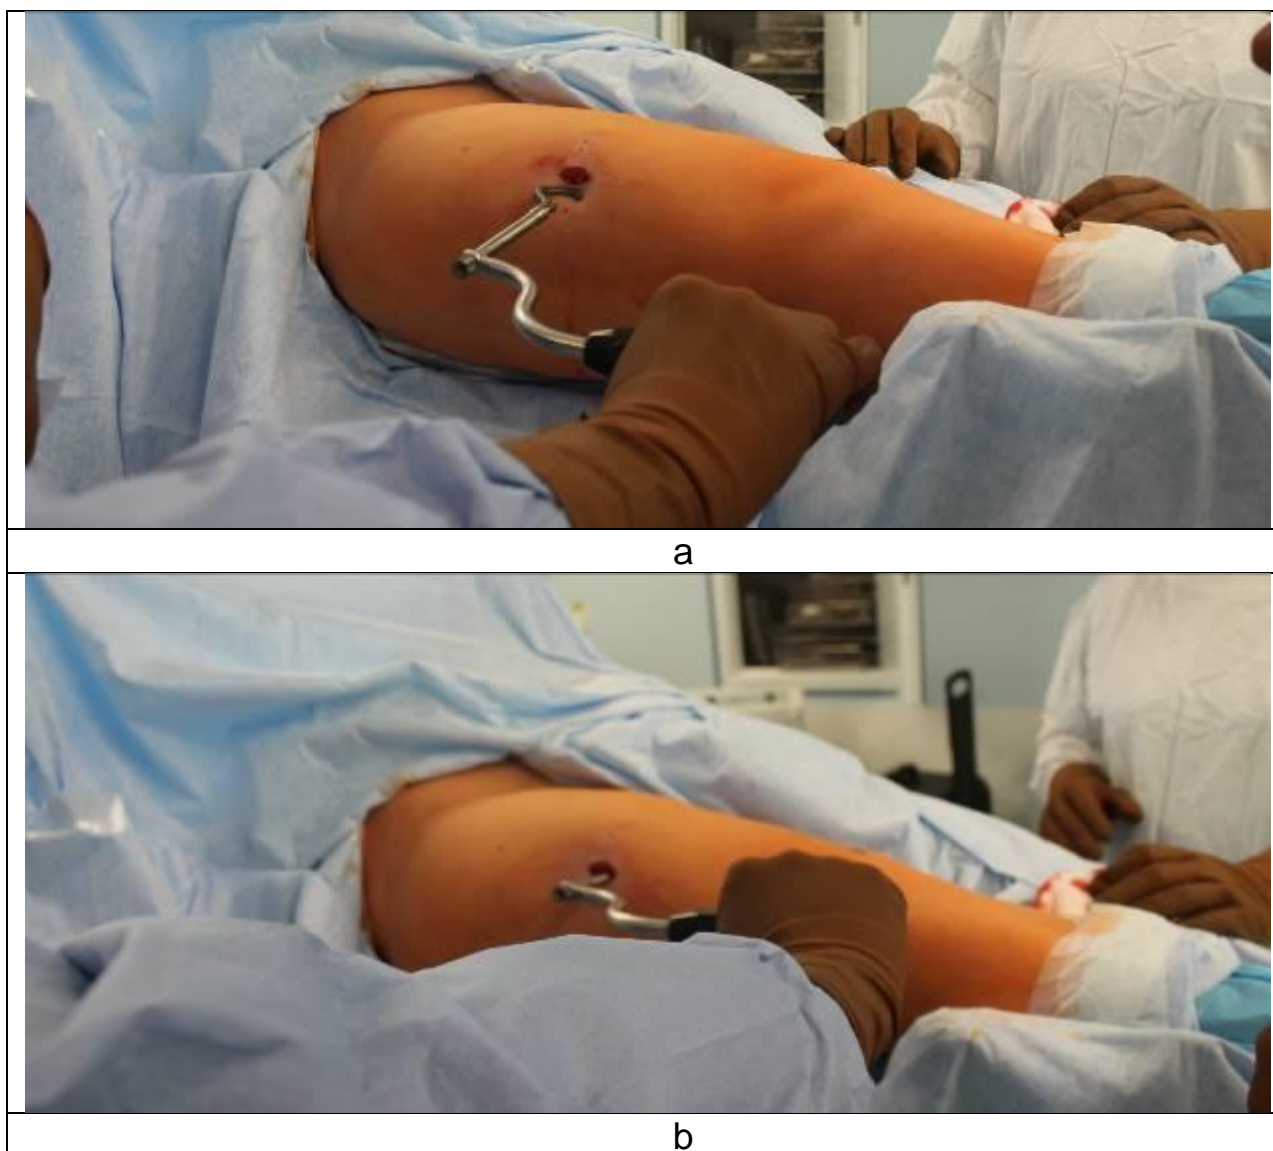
Insertion of SUV-clamp: a,b – insertion of the hook-shaped part of SUV-clamp using Instrument #1
